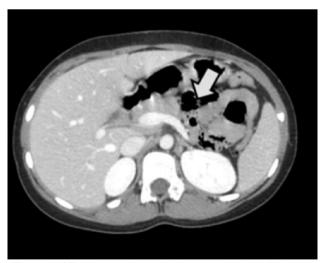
CT abdomen shows distal pancreatic bed is filled with small bowel which is abutting the splenic vein (dependent intestine sign)
